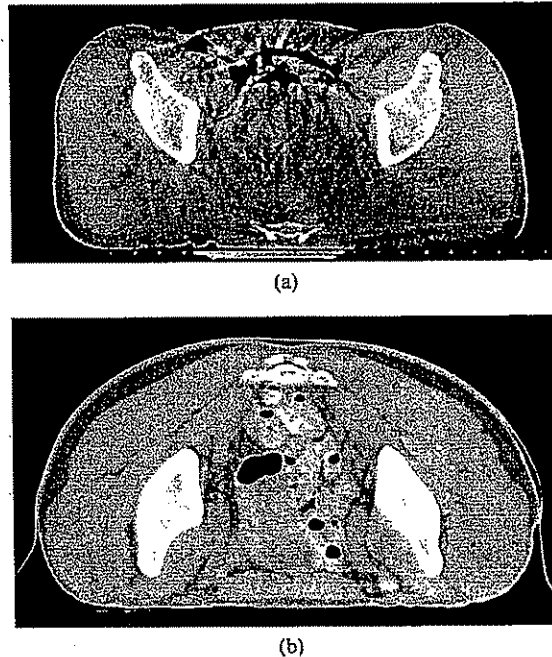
(a) Movement artefacts on an axial slice of a CBCT scan as a result of movement of bowel gas. (b) An axial slice from a planning CT of the pelvis for comparison. (Courtesy of Varian Medical Systems, Palo Alto, CA and Memorial Sloan-Kettering Cancer Centre).
